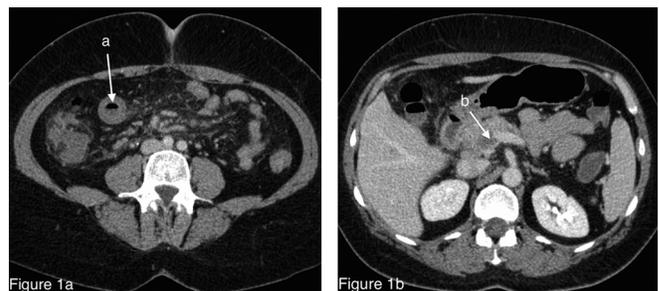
Abdominal CT scan of a 34-year-old female presenting with severe abdominal pain, nausea, and vomiting 5 days after laparoscopic cholecystectomy. A. Bowel wall thickening (arrow a) in contrast-enhanced axial CT scan is shown. B. Thrombosis of the central portal vein (arrow b) in the venous phase is shown.
